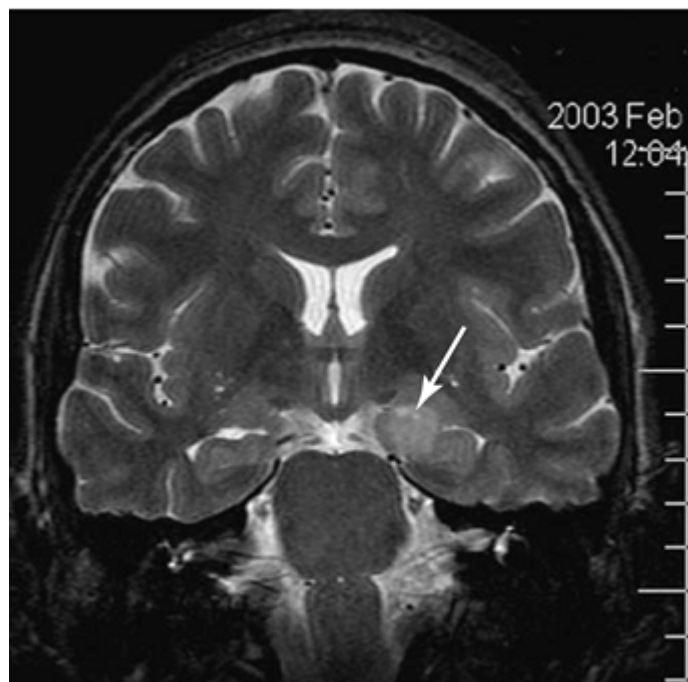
This T2-weighted image shows a dysembryoplastic neuroepithelial tumor in the mesial temporal region, involving the amygdala and the hippocampus on the left side (*arrow*).
